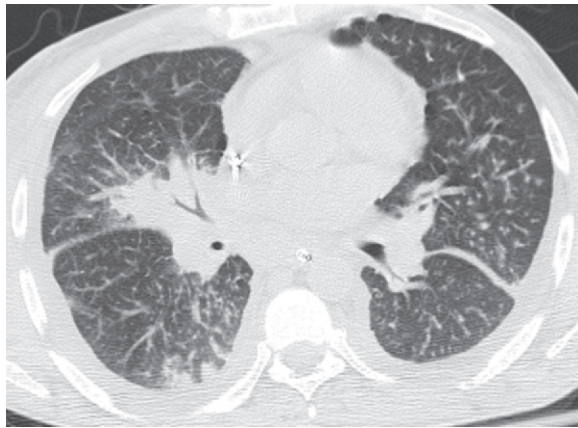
Kaposi sarcoma in a 48-year-old man with a history of over a decade of HIV infection. The patient, who had a CD4 count of 50 cells/ μ L, was receiving ART and presented with acute respiratory distress after 3 weeks of cough and dyspnea. CT image demonstrates flame-shaped peribronchovascular consolidation caused by Kaposi sarcoma. A high level of plasma HHV-8 DNA was detected.
